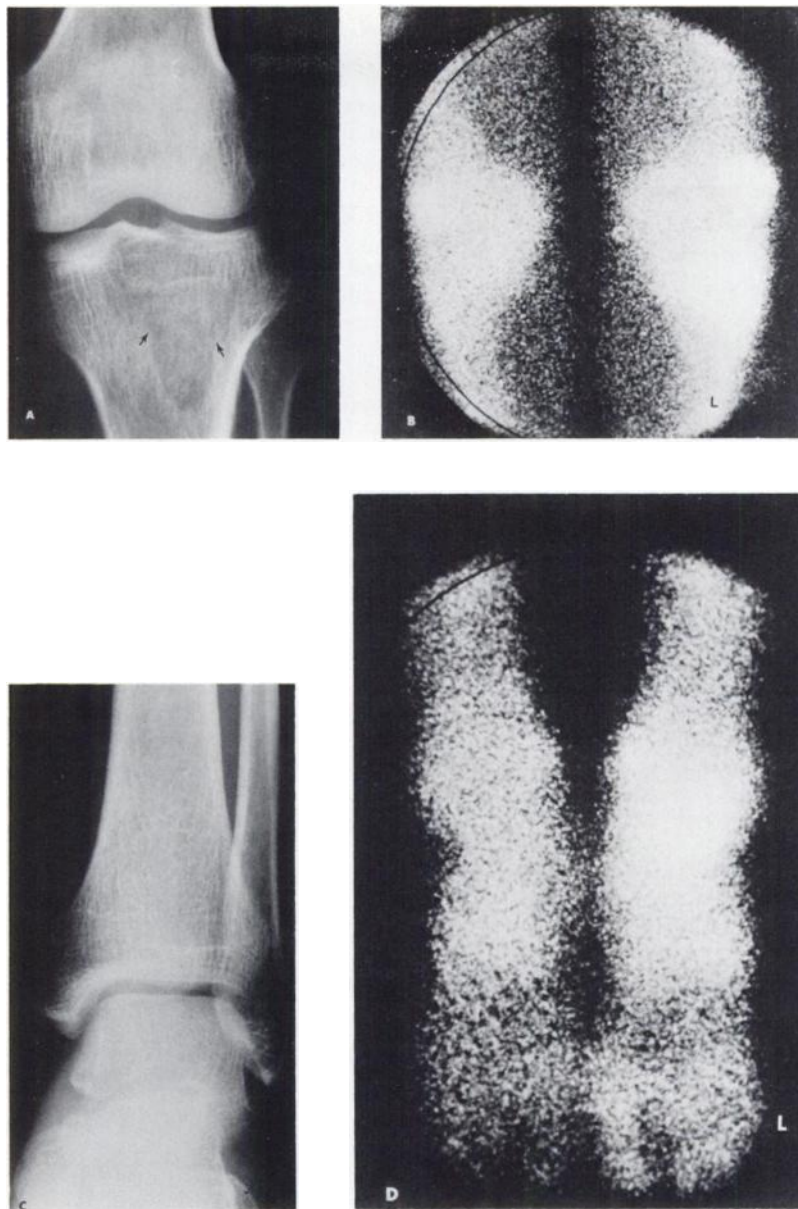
Case 5. (A) A radiograph of left knee reveals a lytic defect in the proximal tibia (arrows). (B) Bone scan demonstrates increased tracer uptake in the proximal tibia and possibly left patella. (L = left.) (C) A radiograph of left ankle is normal. (D) There is increased activity in left ankle.
